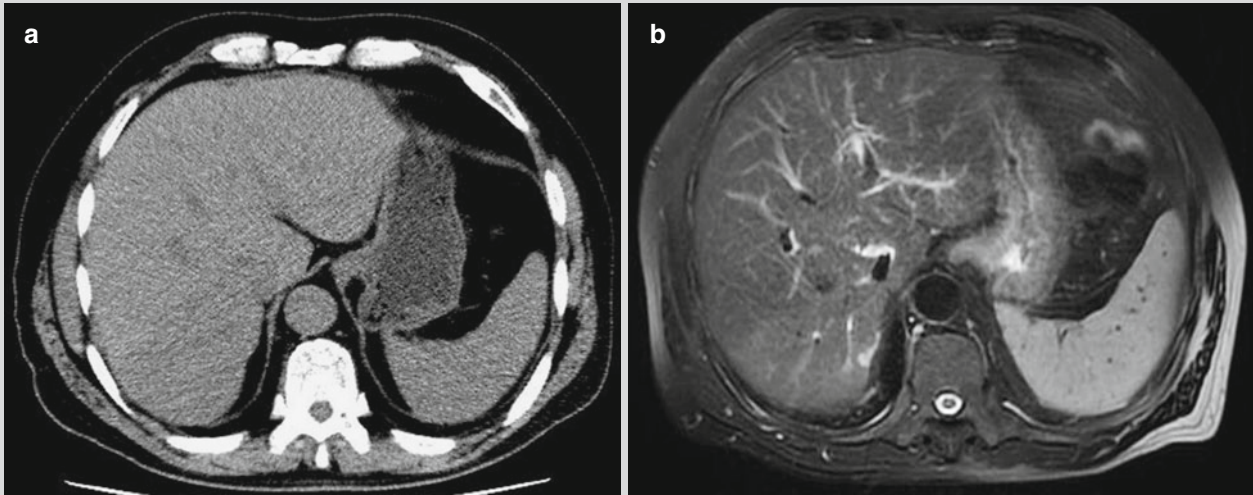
Brucellosis complicated by liver and spleen lesions. (a, b) Both CT scanning and MR imaging demonstrate enlarged liver and spleen, with smooth margin and no abnormal densities and signals
